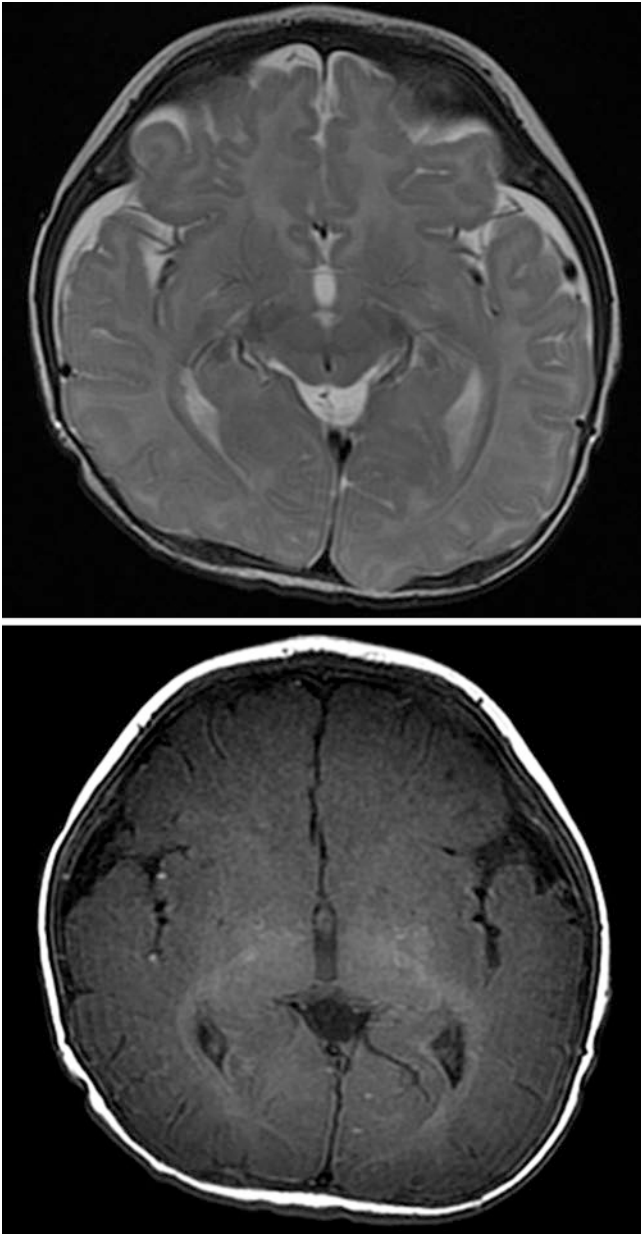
A 2 month old showed flattening on axial T2WI (*top*) and T1WI (*bottom*) MRI
